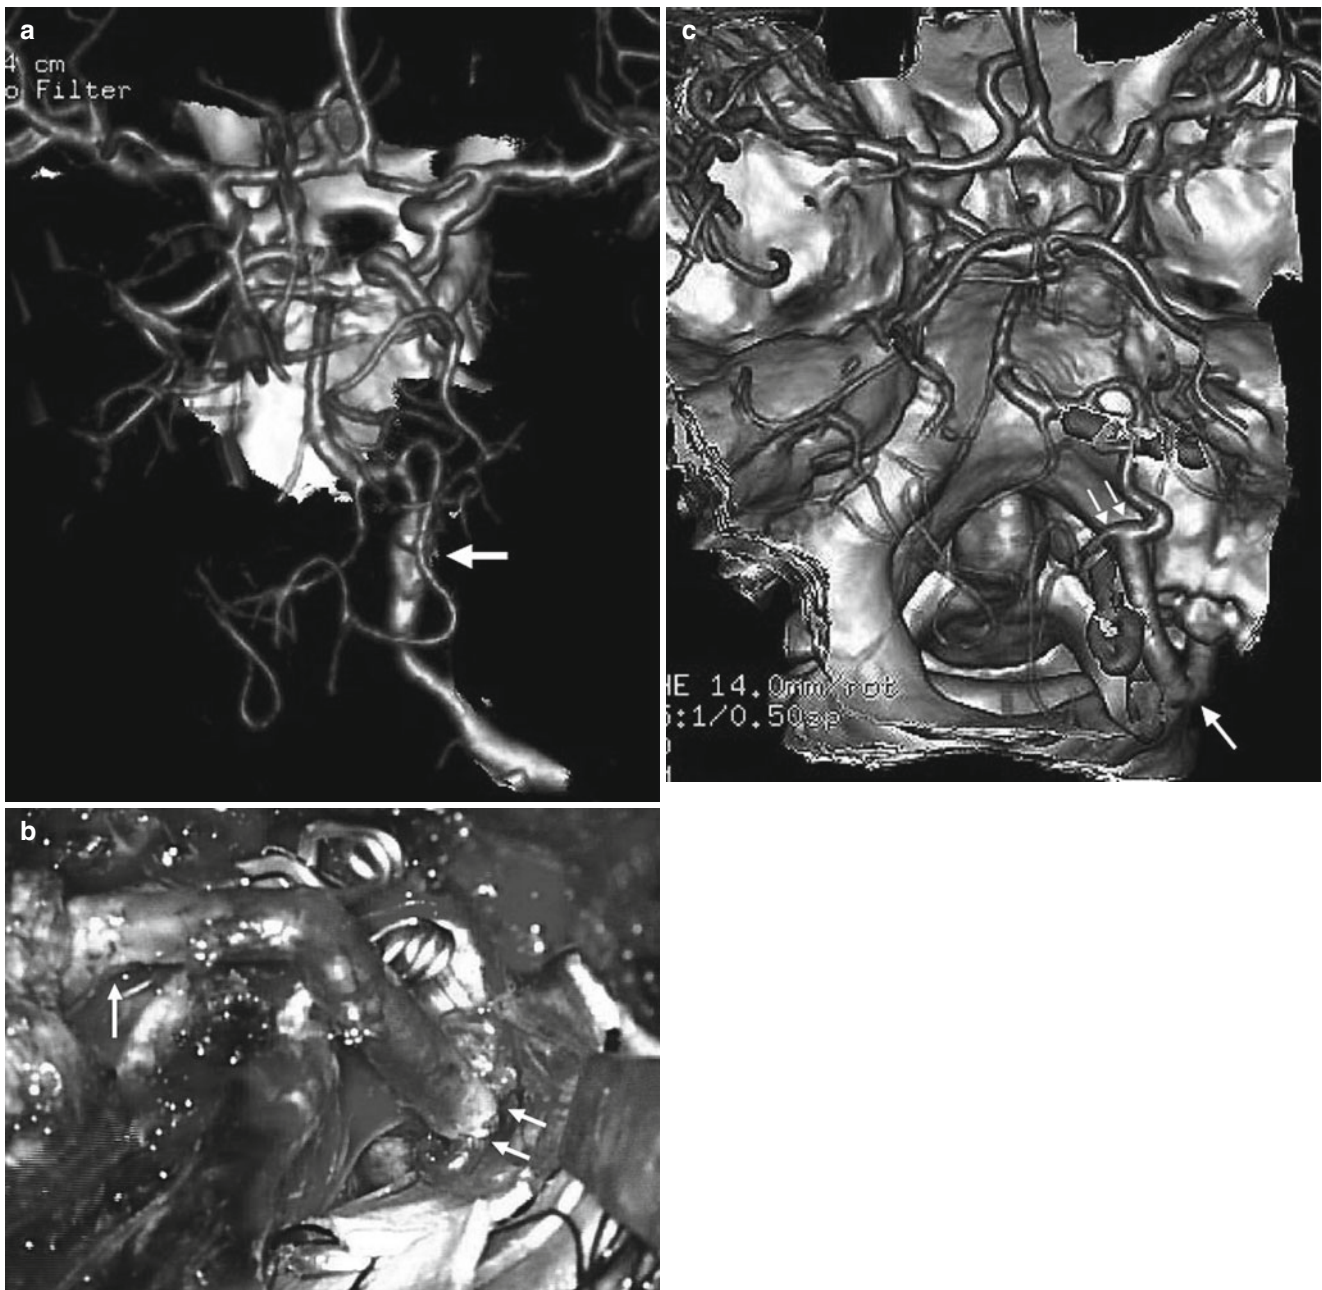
(a) 3D-CTA showing a right VA dissecting aneurysm (*arrow*) with aplastic contralateral VA and bilateral P1 were hypoplastic. (b) An intra-operative photograph demonstrating the extracranial VA (*arrow*) to the PICA (*double arrow*) bypass using an interposition short vein
